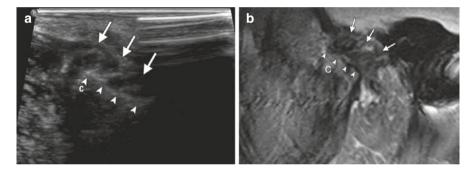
Condylar neck pseudo-articulation in the same patient as shown in Fig. 10.32 following a healed left subcondylar fracture. (a) Sagittal sonogram shows a subcondylar stump (C) and pseudo-articulation (arrowheads) of the stump with the articular eminence that is partially encased in a fibrous ankylosis (arrows) that is hypoechoic. (b) The MR image shows comparable findings. Arrowheads show the pseudo-articulation and subcondylar stump (C). The fibrous ankylosis (arrows) is of low signal intensity by MR
